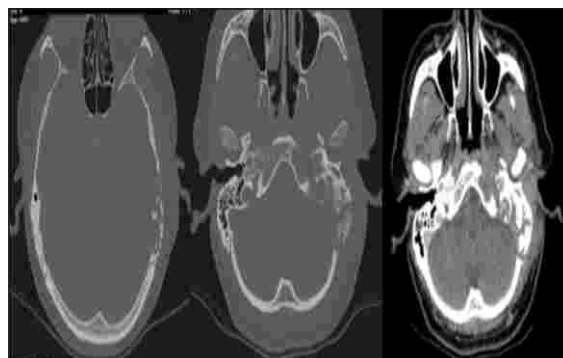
CT temporal bone axial cuts was suggestive of erosion of left squamous, mastoid, lateral petrous and part of petro-clival region. It shows heterogenous destruction where continuity of bone is maintained at places.(W:2800, L:600) (left 2- bony cuts; rightmost- soft tissue window)
